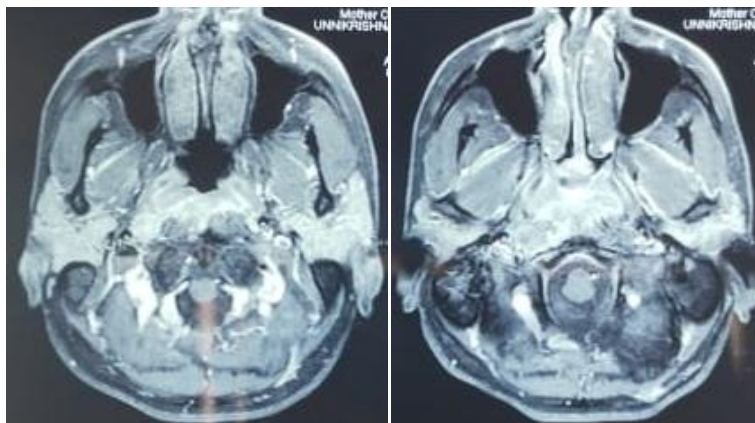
Heterogeneously hyperintense lesion involving posterior and lateral nasopharyngeal wall in T2W MRI brain
